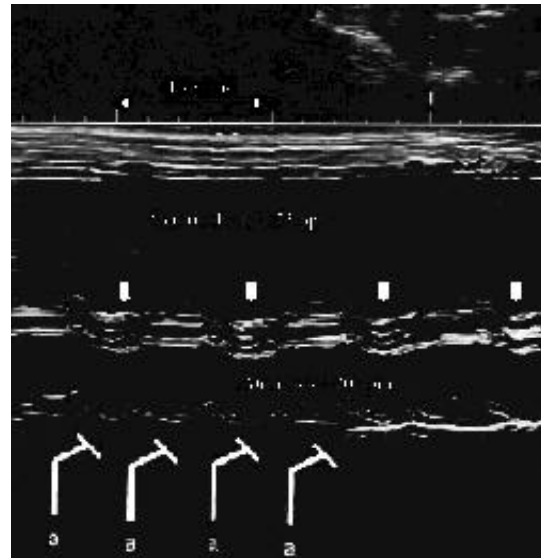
A complete atrioventricular block in a 31-week-old fetus whose mother had positive Ro-SS-A antibodies. Atrial rate was 120 and ventricular rate was 75 beats per minute. Note atrioventricular dissociation. This fetus was followed with frequent echocardiographic examination for a development of heart failure and hydrops until delivery at 39 weeks of gestation. Permanent pacemaker was inserted in the first week of life. A, atrial contractions, arrows ventricular contractions.
